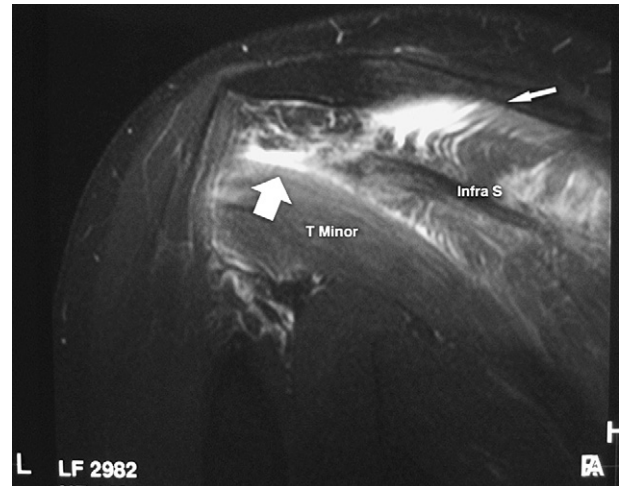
Axial T2 weighted MRI scan showing edema in the infraspinatus muscle in association with retraction and thickening of the aponeurosis (white arrow). (Patient 19, Table I): T minor, Teres Minor; S Scap, Subscapularis.
